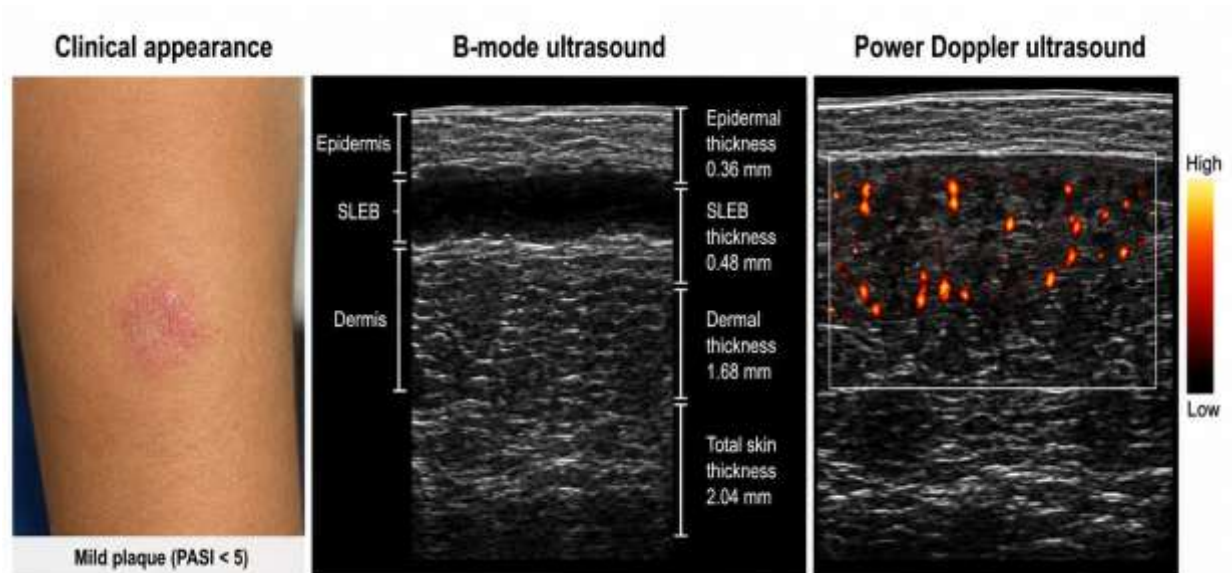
Representative case of clinically mild psoriasis demonstrating prominent SLEB and dermal Power Doppler vascularity despite limited visible clinical inflammation.
